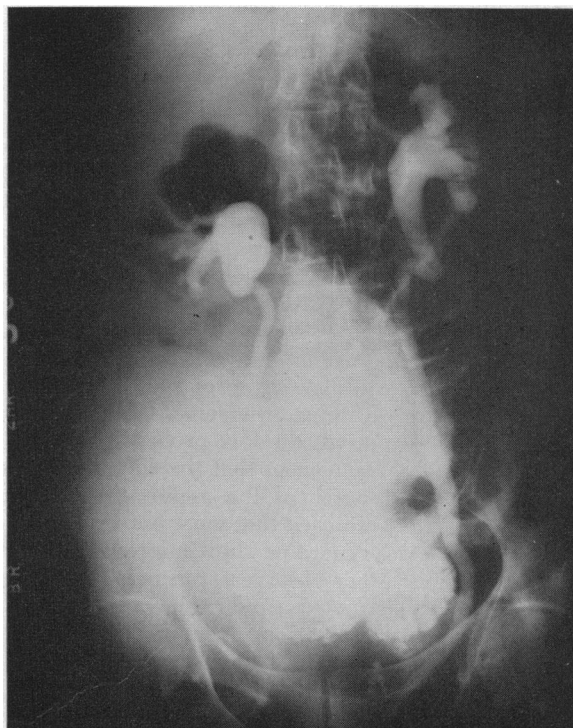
Roentgenogram demonstrating bilateral hydronephrosis and hydroureter. Calcified leiomyomata overlie the pelvis. The ovarian fibroma displaces the intestinal loops to the left.
